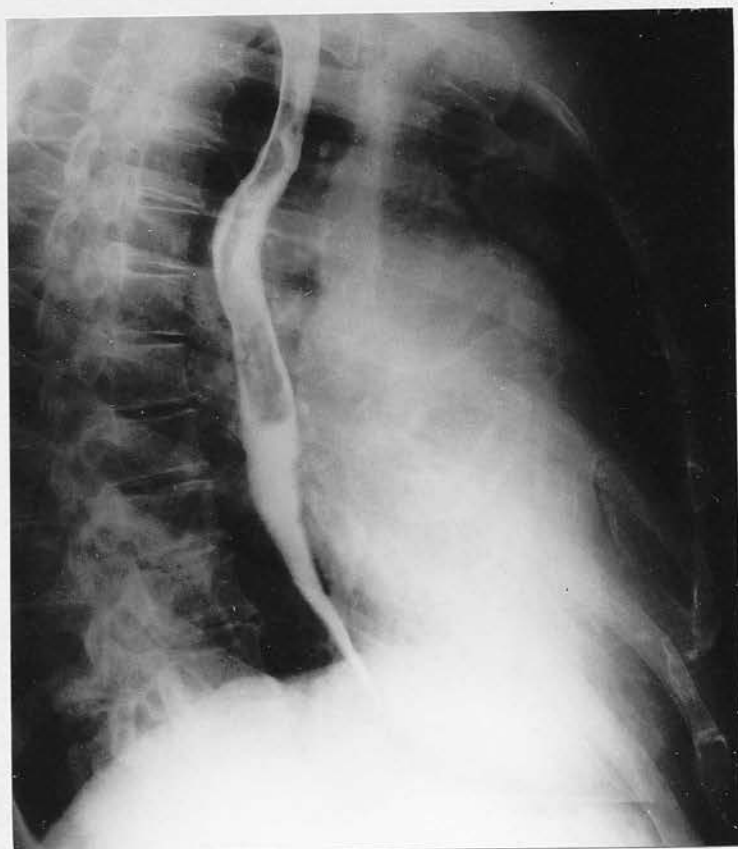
Radiograph of Case 71. Patent Ductus aged 64yrs. with calcification in Arch of Aorta.
